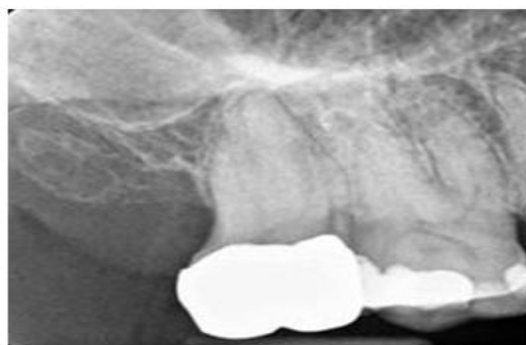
Following the placement of a full gold crown on the maxillary right second molar, the patient complained of sensitivity to both hot and cold liquids; now the discomfort is spontaneous. Upon application of Endo-Ice on this tooth, the patient experienced pain and upon removal of the stimulus, the discomfort lingered for 12 seconds. Responses to both percussion and palpation were normal; radiographically, there was no evidence of osseous changes. Diagnosis: Symptomatic irreversible pulpitis normal apical tissues.
